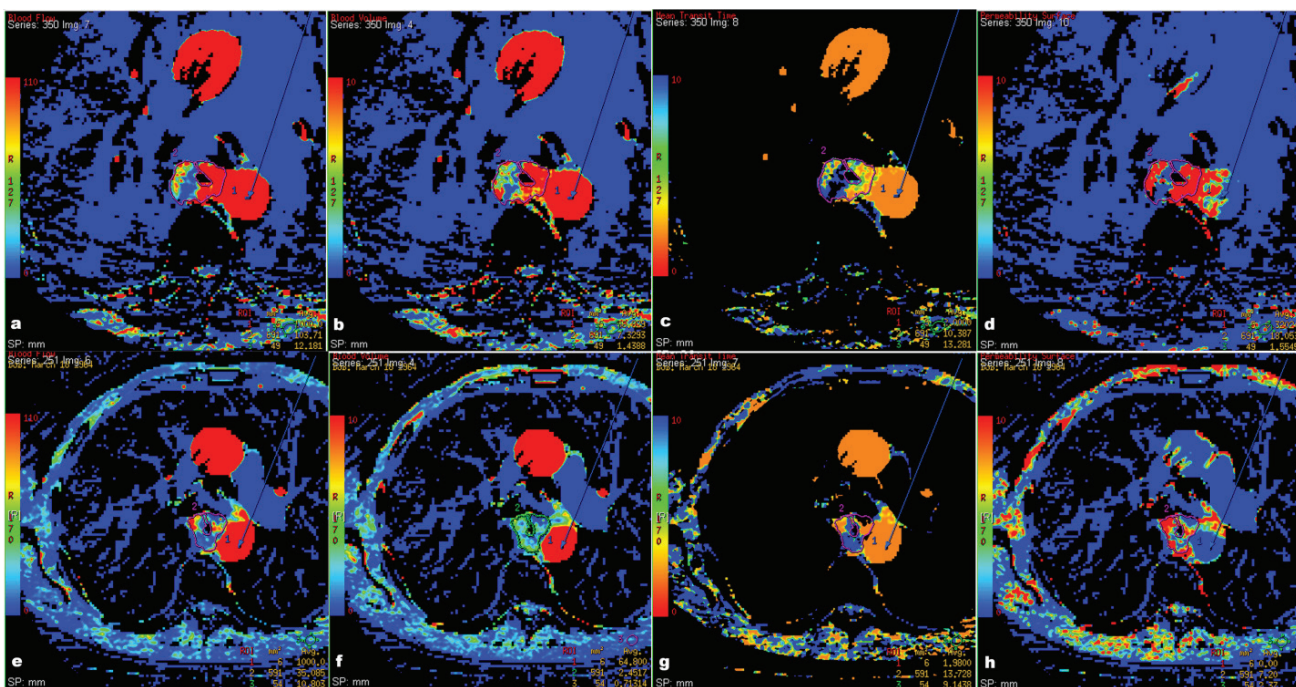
CT perfusion parameter values (BF, BV, MTT, and PS) of the esophageal SCC: (a-d) before and (e-h) after the neoadjuvant CRT (Images are the author's work, and written informed consent for publishing their anonymous images was obtained from a patient)
